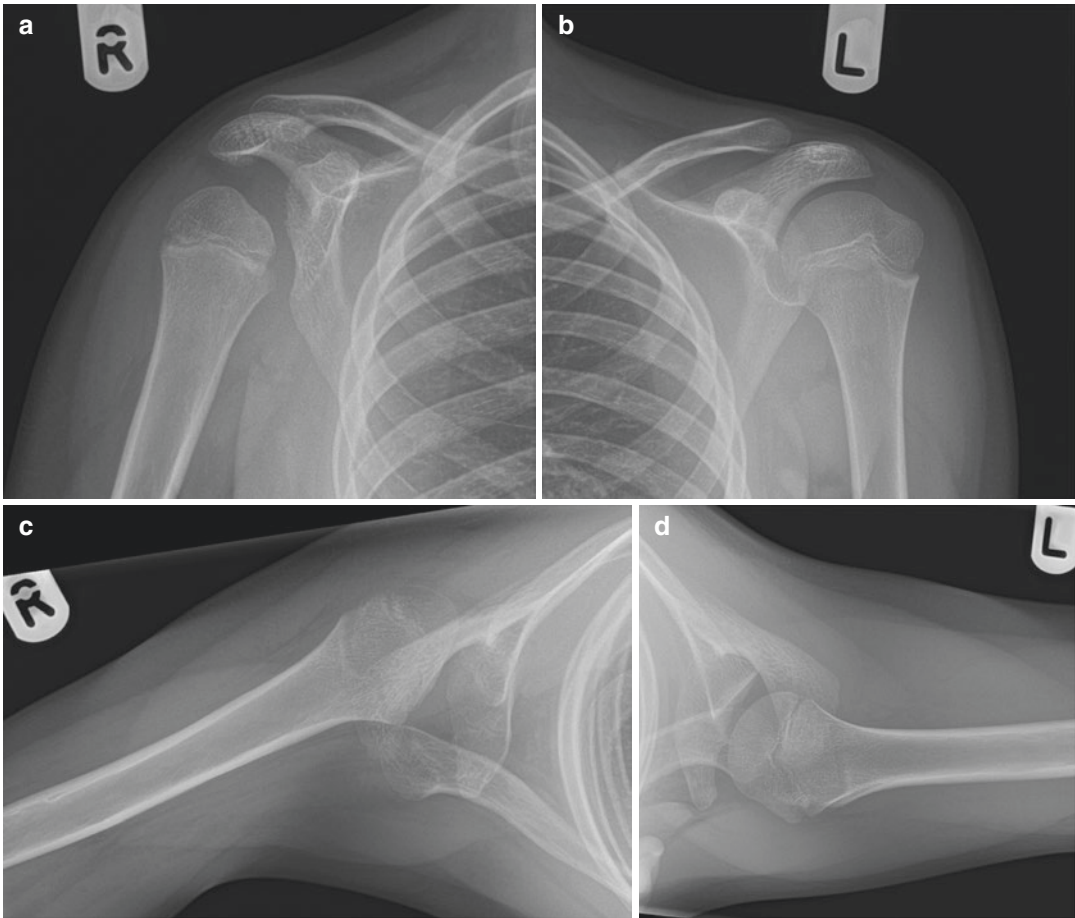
Anteroposterior (a, b) and axillary lateral radiographs (c, d) of both shoulders in a child with BPBI at age 12 years. There is posterior dislocation of the right shoulder which has not been treated
